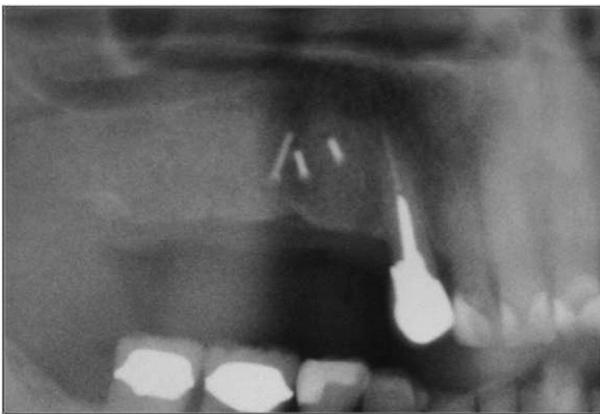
Preimplant panoramic radiograph 6 months after MTBBG. Three fixation screws can be seen. Radiographically, the grafted bone looks similar to the adjacent alveolar bone.
